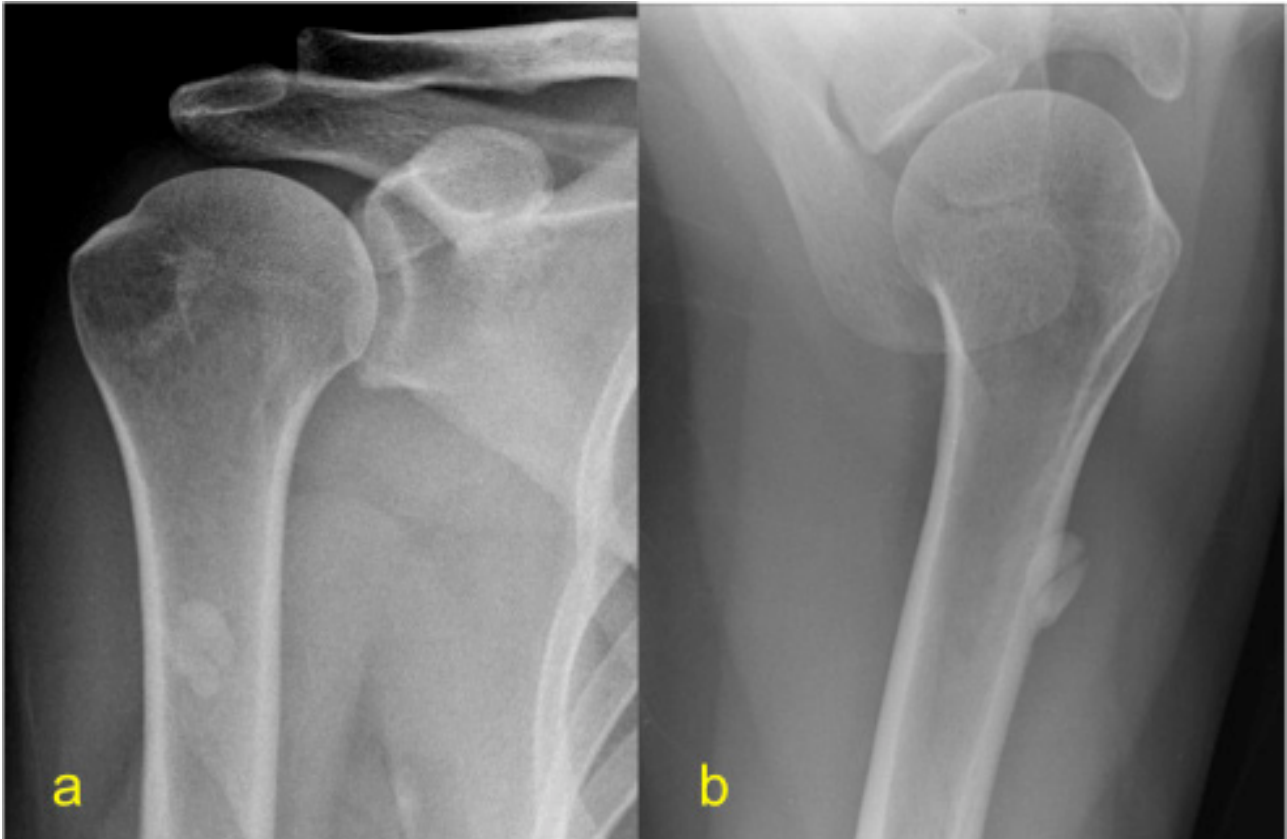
a. Antero-posterior (a) and Axillary (b) radiograph of the proximal humerus demonstrating a 2cm bilobulated calcific lesion over the LHB tendon.
